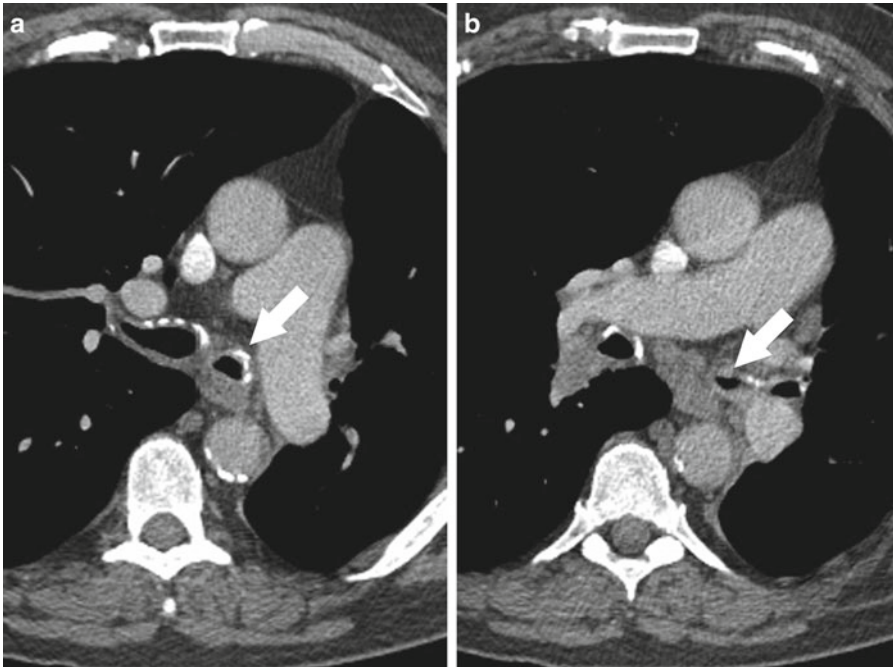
Bronchial stenosis following mediastinal and left hilar radiation for lung carcinoma. (a, b) Contrast-enhanced CT scan images show narrowing of the left main bronchus (*arrows*) with mild mural thickening
